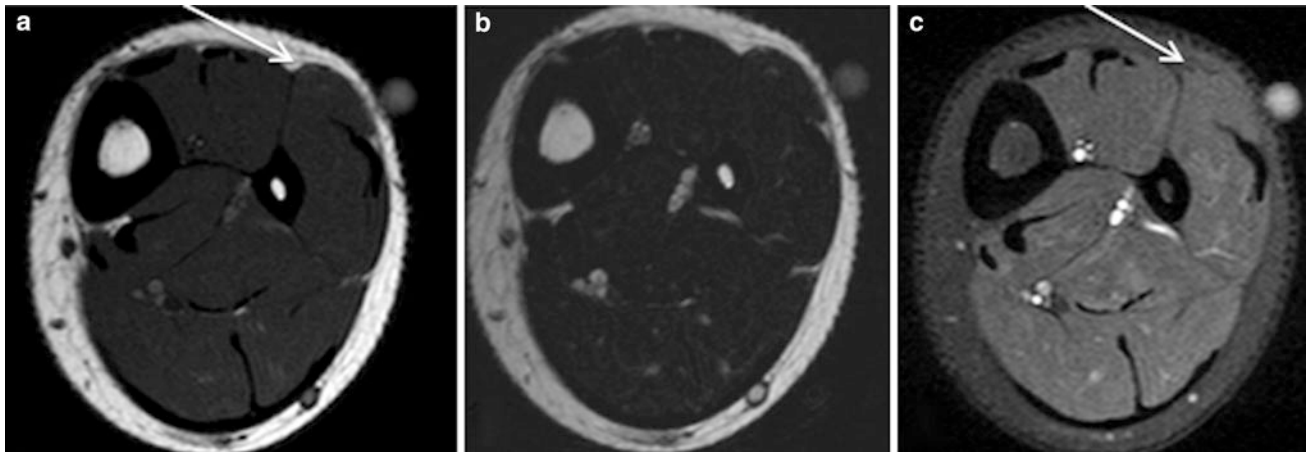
A 16-year-old kickboxer with a suspected “tumour” of the lateral leg, location marked with a capsule. Axial T1 (a), T2 (b) and post contrast T1-weighted MR images with fat saturation demonstrates a muscle hernia of the peroneus longus muscle with outpouching of the muscle through the investing fascia antero-laterally. The hernia
